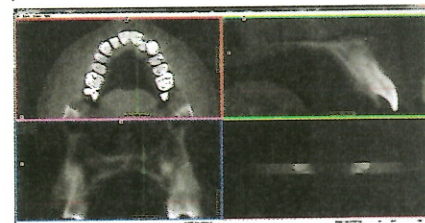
DICOM file of the cone-beam computed tomography (CBCT) scan.
